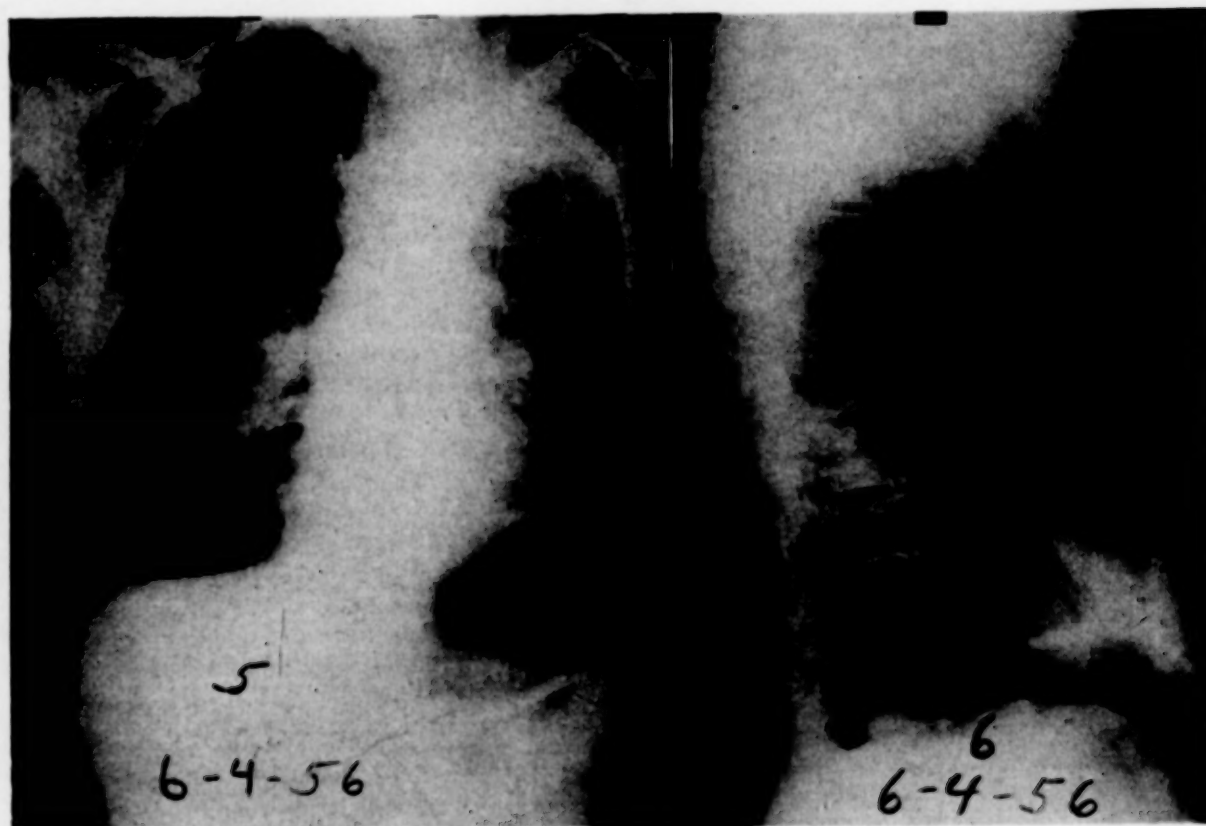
CASE IV. Postoperative roentgenograms following thoracoplasty.
